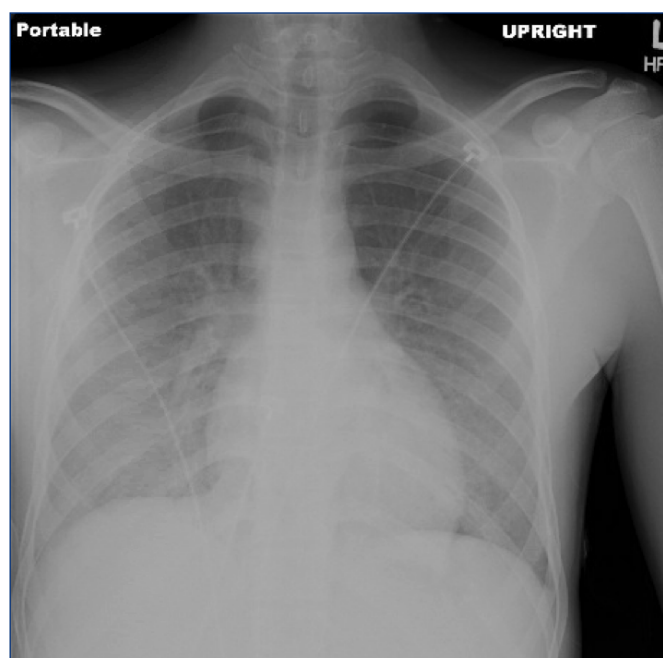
A portable AP Chest Radiograph on admission showing moderate bilateral pulmonary infiltrates.
